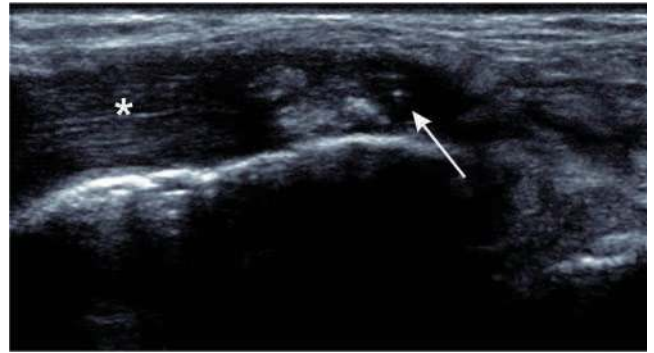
Full thickness tear of tibialis posterior. Longitudinal ultrasound shows fluid and debris within the tendon sheath (arrow) with tendinopathy of the adjacent tendon (asterisk).
